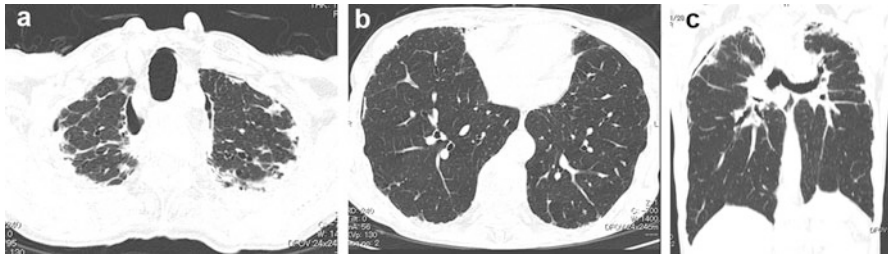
Pleuroparenchymal fibroelastosis (PPFE). (a) High-resolution computed tomography (HRCT) at the pulmonary apex shows subpleural atelectatic fibrosis. (b) HRCT at the pulmonary base shows subpleural fibrosis that suggests a usual interstitial pneumonia (UIP) pattern. (c) Reformatted coronal CT image shows marked volume loss in bilateral upper lobes with elevation of the pulmonary hili
